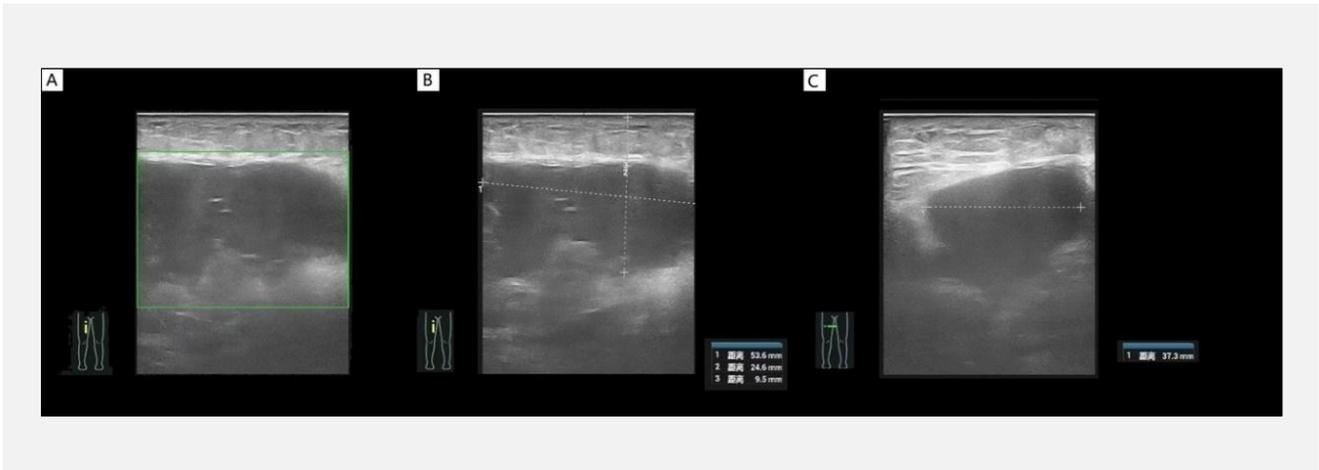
B-ultrasonic of the mass on the right thigh shows the size of the hematoma.
